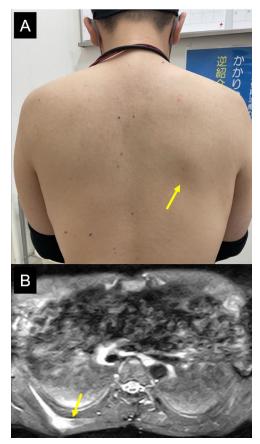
Clinical photograph of the scapula. The inferior pole of the right scapula (arrow) was more lateral than the left scapula, and a dent suggestive of muscle rupture was observed on the medial scapula border (A). Magnetic resonance image of the periscapular muscles. The image with short inversion time inversion recovery technique shows a tear of the right rhomboid major at its insertion (arrow) with surrounding fluid retention (B).
